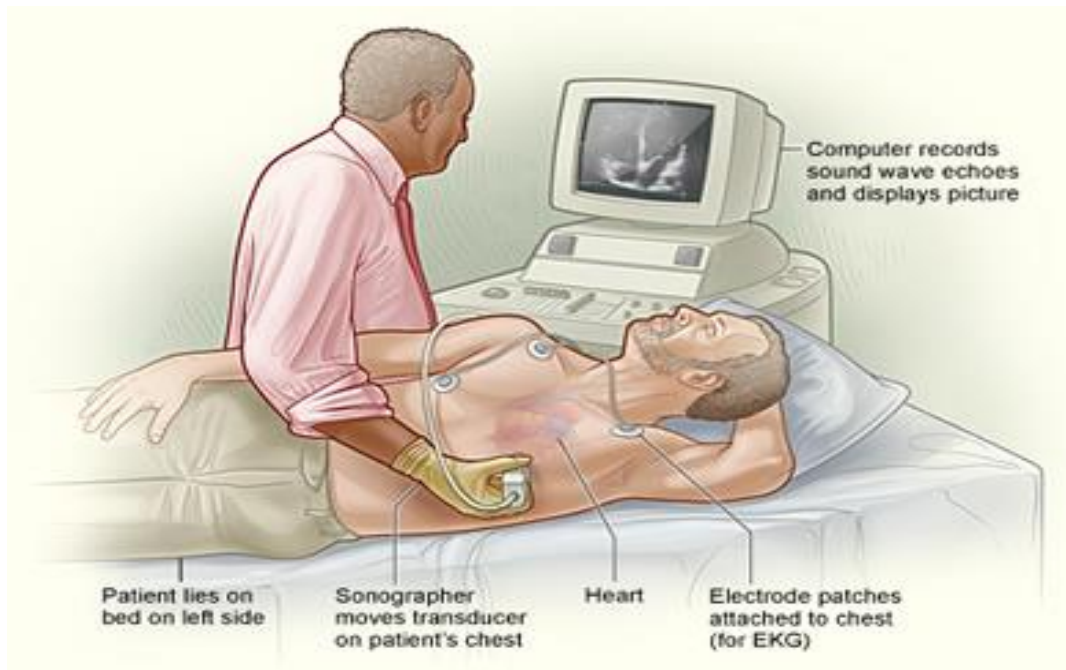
Position during Echocardiography. The patient lies on his left side. A sonographer moves the transducer on the patient's chest, while viewing the pictures from the echocardiography on a computer. Echocardiography. www.nhlbi.nih.gov [138].
